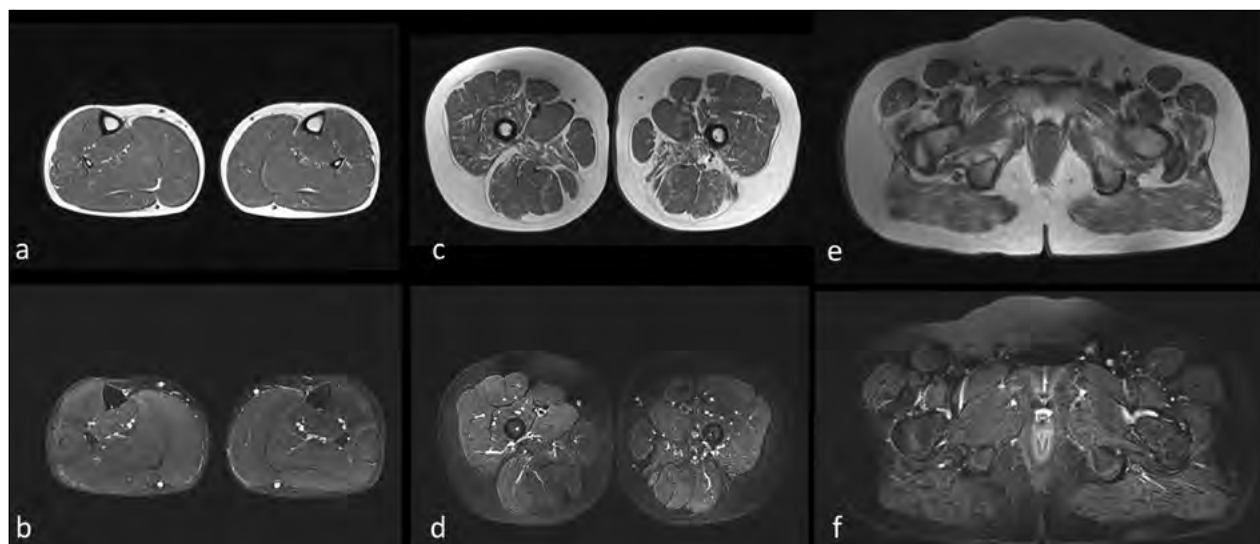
Muscle MRI. Muscle MRI findings performed at the age of 12 years and 3 months. (A,C,E) Axial turbo spin echo T2 weighted (w), and (B,D,F) short tau inversion recovery (STIR) axial images at the level of the lower leg (A,B), thigh (C,D) and pelvic girdle (E,F) are shown. No significant fat substitution or edema is evident at the level of the leg muscles, in which, by contrast, a mild triceps surae hypertrophy can be detected (A,B). At the level of the thigh (C,D) the adductor magnus, vastus lateralis and intermedius show signs of fat substitution bilaterally, without associated muscle edema. At the level of the pelvic girdle the involvement of the glutei is evident with fat substitution (E) and no corresponding edema (F).
